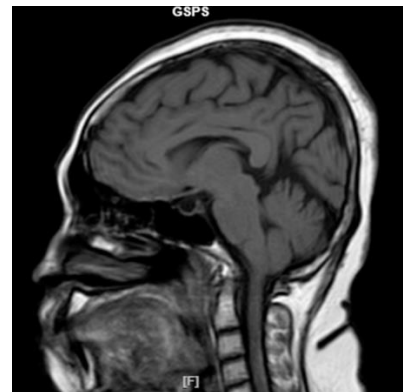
MRI without IV contrast of our patient for the last follow-up visit showed empty sella syndrome (white arrow) without signs of intracranial SOL, bleeding or infarction
